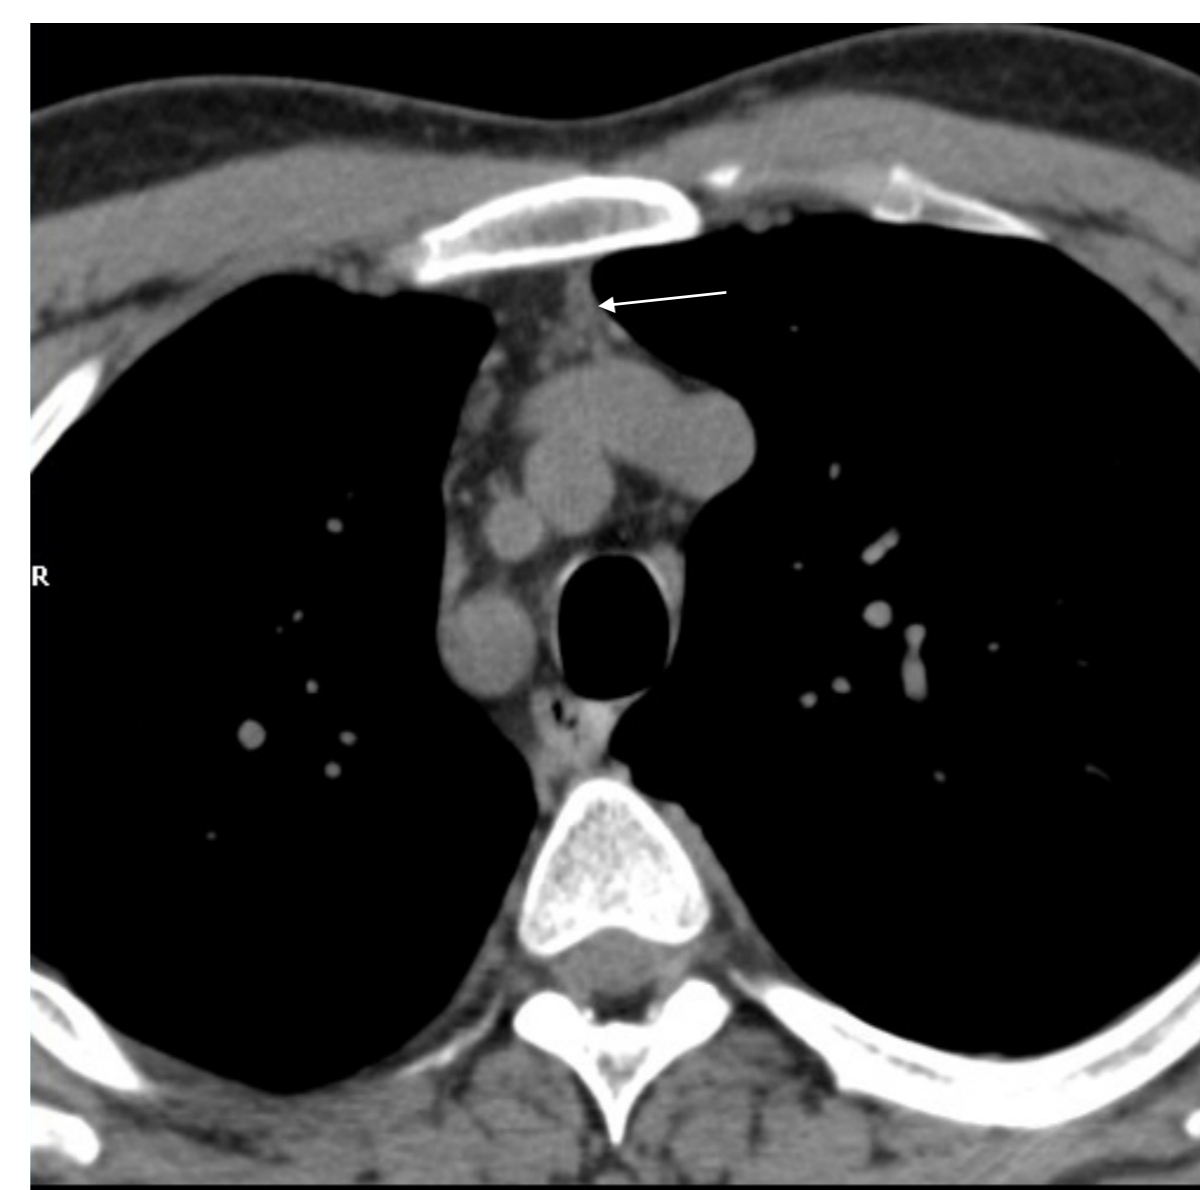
CT image after 4 months of MTZ: shrinkage of the thymus mass.
